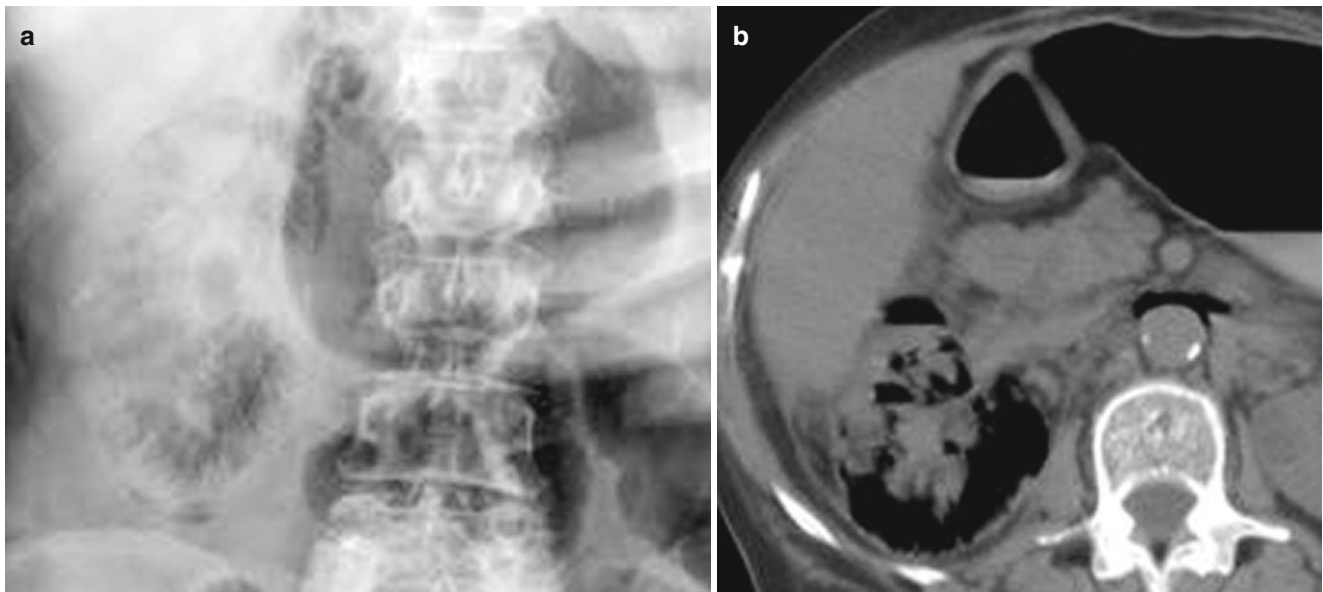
Emphysematous pyelonephritis. (a) Scout image shows mottled lucencies projecting over the right renal shadow. (b) Non-contrast-enhanced axial CT image of the same patient demonstrates gas
